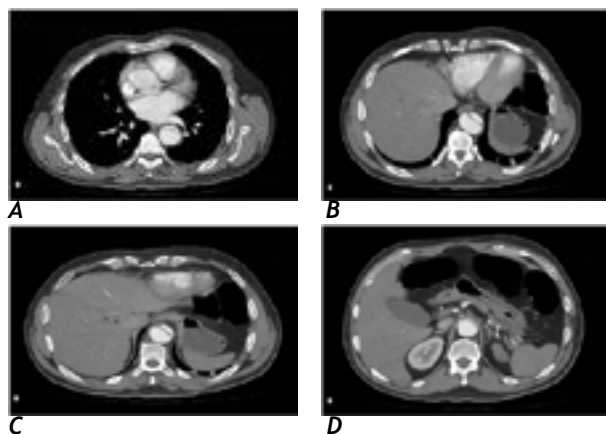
CT angiography showed Stanford Type B aortic dissection; starting from the aortic arc and reaching distal to the left renal artery. (A-D)
